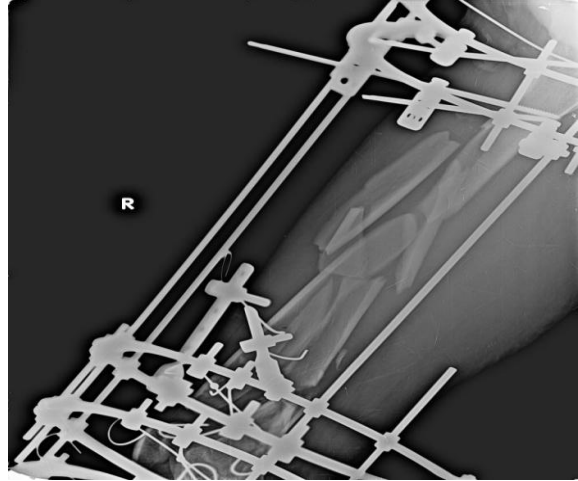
comminuted femur # pre and post operative x-rays
